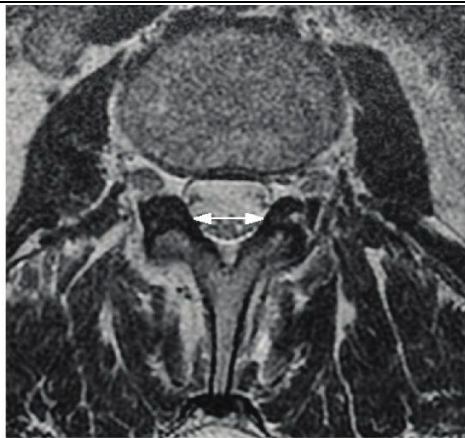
T2 weighted transaxial fast spin echo MR image of the lumbar spine at the level of L3. The white arrow indicates the transverse diameter of the osseous spinal canal.
